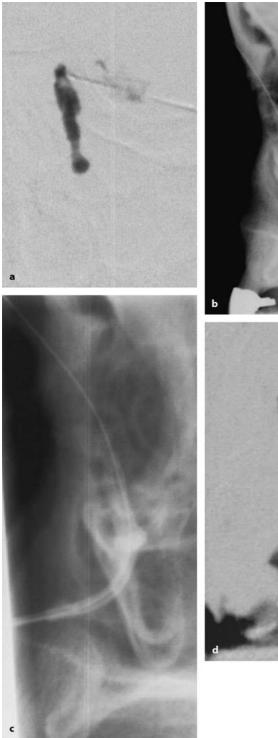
a Dacryocystography (frontal view) shows complete obstruction of the left nasolacrimal duct system (a). b Radiograph (lateral view) obtained after recanalization of the obstruction demonstrates a 0.018 in. ball-tipped guide wire which is introduced into the nasolacrimal duct system and gently advanced until reaching the inferior meatus of the nasal cavity (b). c Stent implantation (lateral view): From distal the stent retrogradely advanced over the guide wire until correct position of the stent is achieved. d Dacryocystography after stent implantation shows a patent stent with contrast medium passage through the stent into the inferior meatus of the nasal cavity
